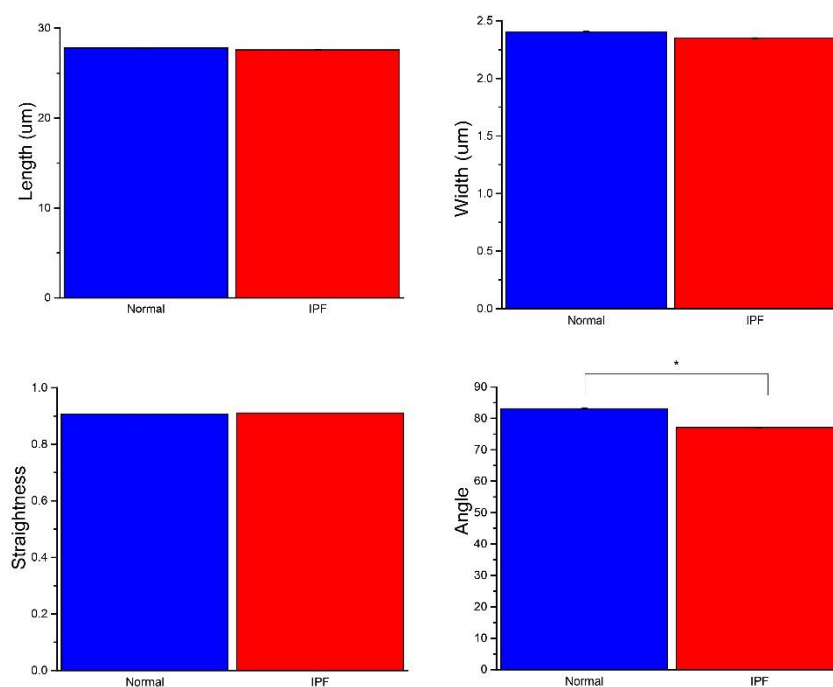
Average CT-FIRE data for normal (blue) and IPF (red) from all lung samples. Standard error bars are shown. * denotes p-values < 0.5 .
